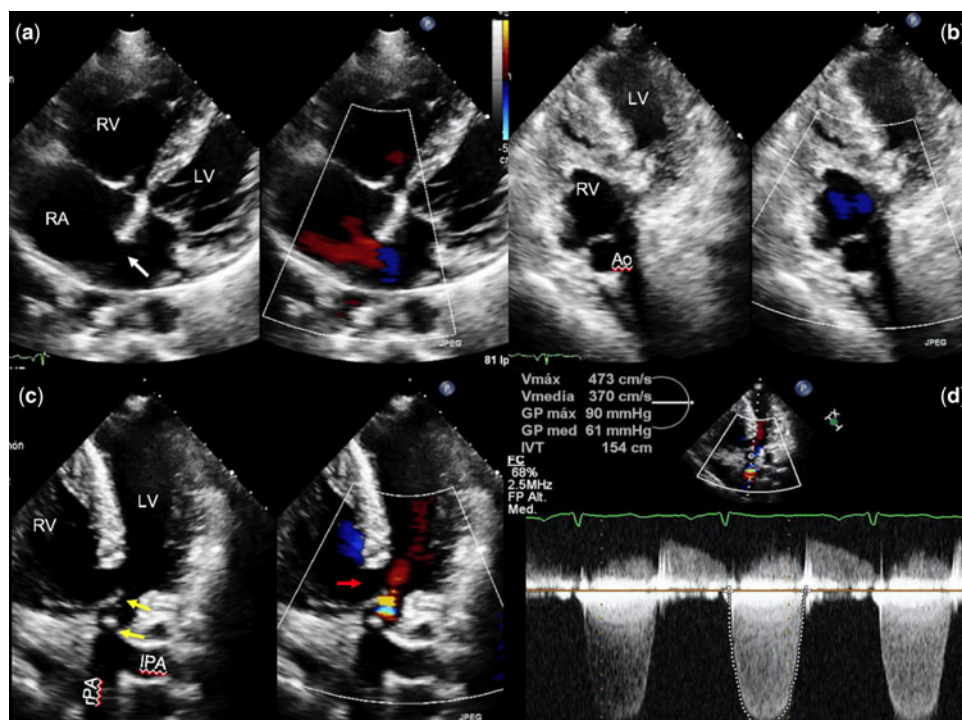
(a) Transthoracic echocardiogram in four-chamber view showing atrioventricular concordance and atrial septal defect (white arrow). (b, c) Ventriculo-arterial discordance in bidimensional and color flow Doppler five-chamber view (clips 1 and 2). Subvalvular and valvular pulmonary stenosis and mild pulmonary regurgitation (yellow arrows) and ventricular septal defect (red arrow) are visualised. (d) In five-chamber view with continuous wave Doppler, a double pulmonary lesion was documented with severe pulmonary stenosis. RA, right atrium; RV, right ventricle; LV, left ventricle; Ao, aorta; rPA, right pulmonary artery; lPA, left pulmonary artery; Vmax, maximum velocity; Vmedia, mean velocity; GP max, maximum gradient; GP med, mean gradient; ITV, velocity time integral; FC, heart rate; FP, filling pressure
